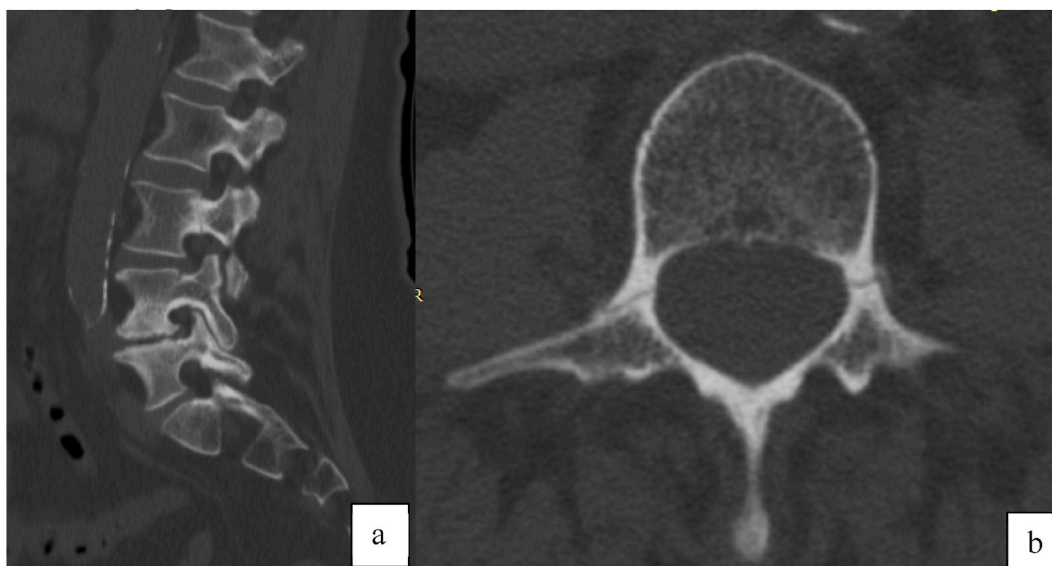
a, b: CT scan with fracture line on both L3 pedicles. Pedicles are characterised as narrow and “corticalised”. These radiographic features are resumed in [Table 1](#).
